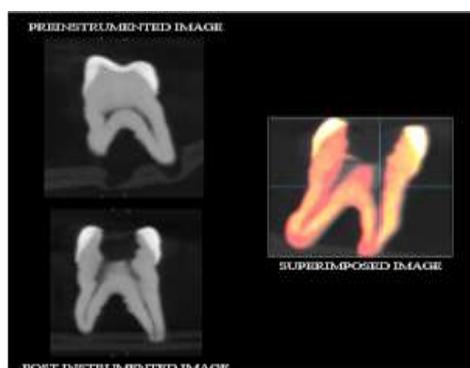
Superimposition of the Preinstrumented and the Post instrumented CBCT image
